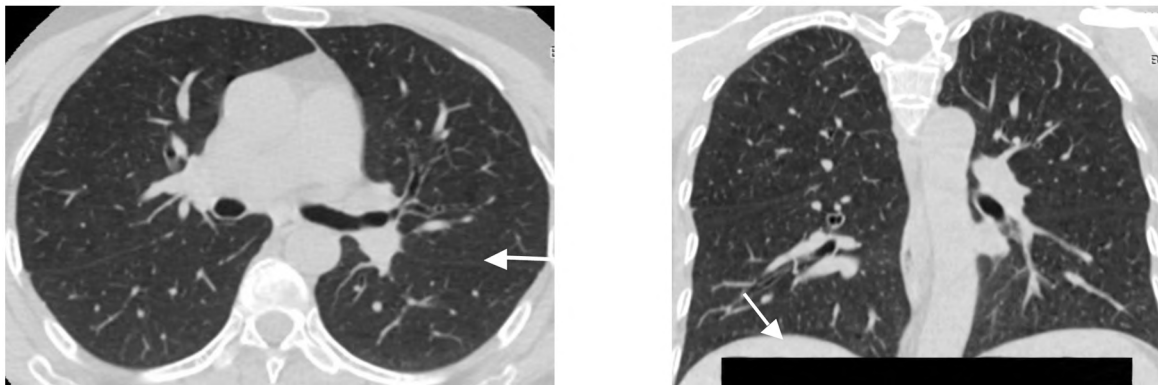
Axial and coronal non contrast CT images in 32 years old man imaged 3 days from symptoms onset (early phase) with CO-RADS 2, shows bilateral bronchial wall thickening (white arrow).
